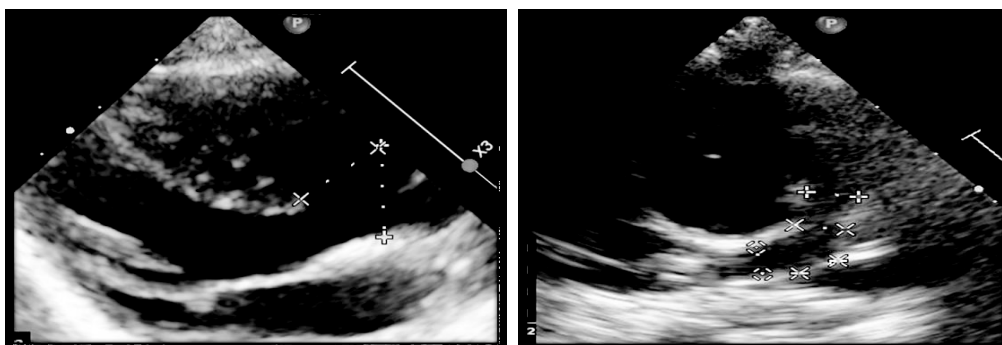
Transthoracic Echocardiography (TTE) images show, (a) para sternal long axis view shows pulmonary annulus (measured along the solid line); (b) Short axis view shows main pulmonary artery (1), left pulmonary artery (2) & right pulmonary artery (3).
